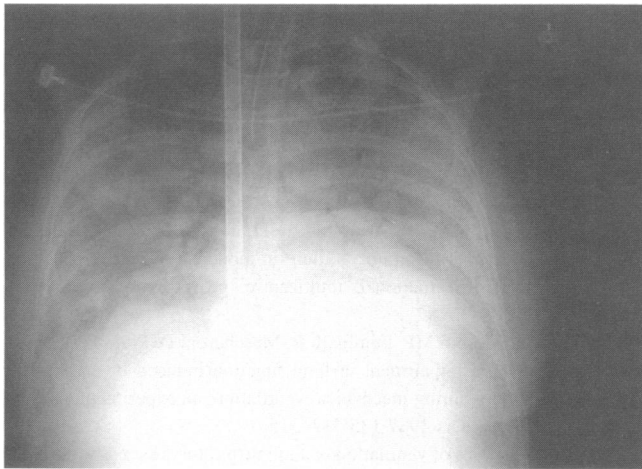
Chest x-ray showing severe adult respiratory disease syndrome and extracorporeal membrane oxygenation cannula position in patient 1.
